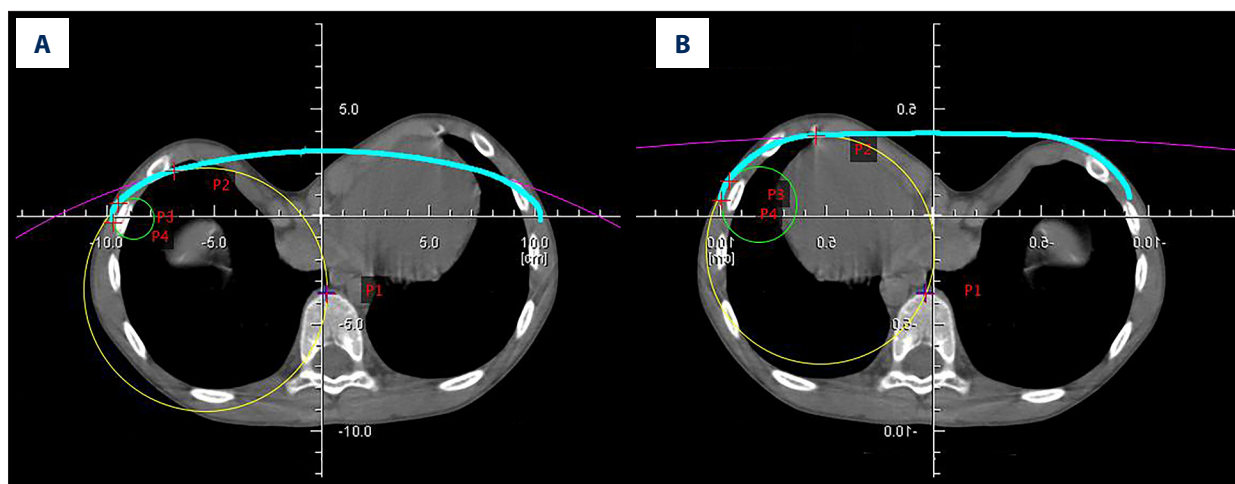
Planning in asymmetry. (A) Asymmetry in a CT scan of a patient with pectus excavatum; (B) mirrored scan of (A). The model can be used in cases of asymmetrical deformities as well. The software can perform the construction from the radiological right side, as in the images from the left side. In cases of asymmetry, the construction begins from the more favorable chest shape. If necessary, the software can mirror the image along the Y-axis. The software used for figure creation was Phytton.
